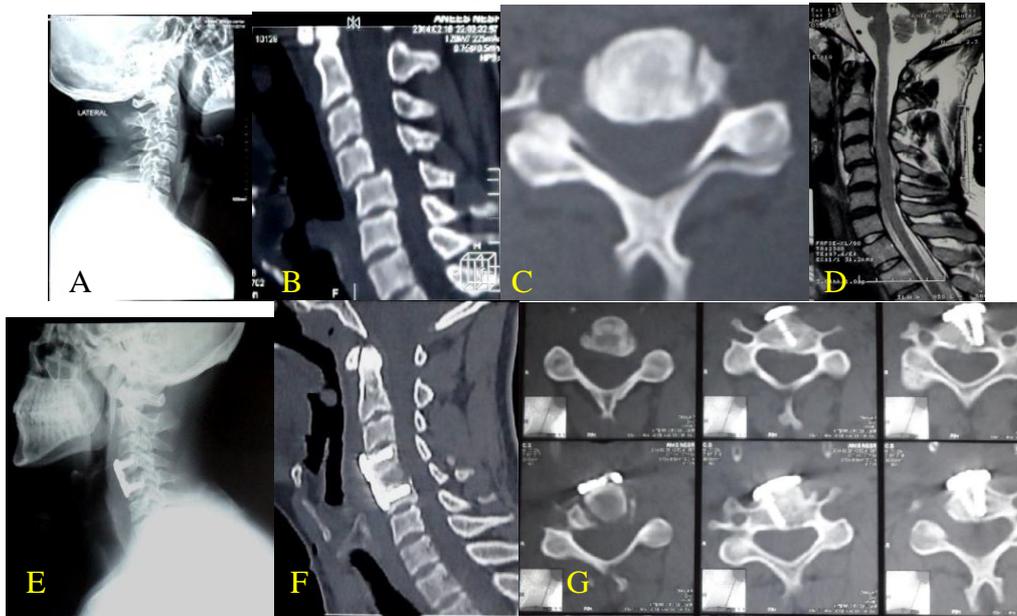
Male patient of 24 years old with history of road traffic accident, Left radiculomyelopathy, (C4-5 dislocation and left unilateral locked facet). (A)pre-operative cervical spine X-ray, (B)sagittal CT scan, (C) axial CT scan,(D)sagittal MRI, and post-operative, (E)X-ray and(F)sagittal CT scan and (G) axial CT scan.
